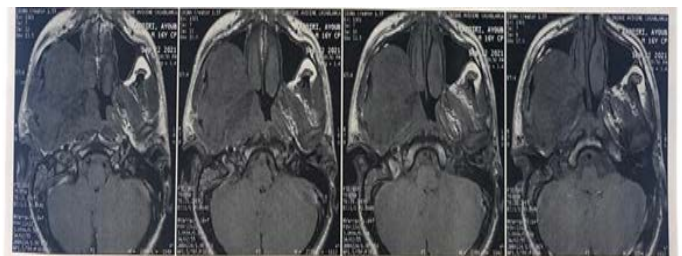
MRI on axial section showing the infiltration of the right maxillary sinus.
